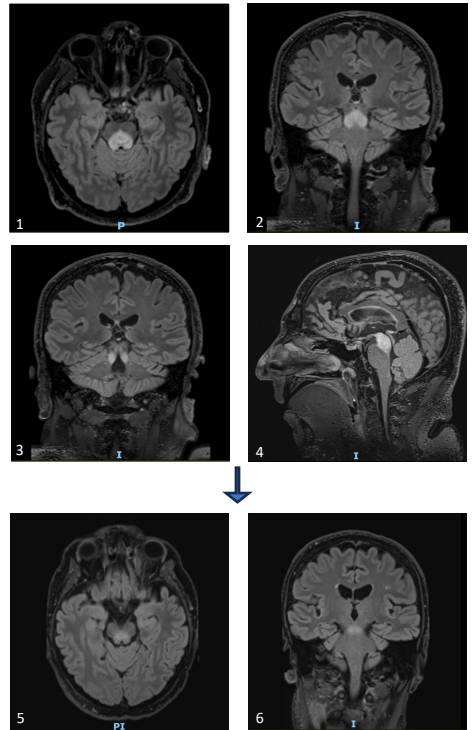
MRI symmetrical mesencephalic T2 hyperintensity
